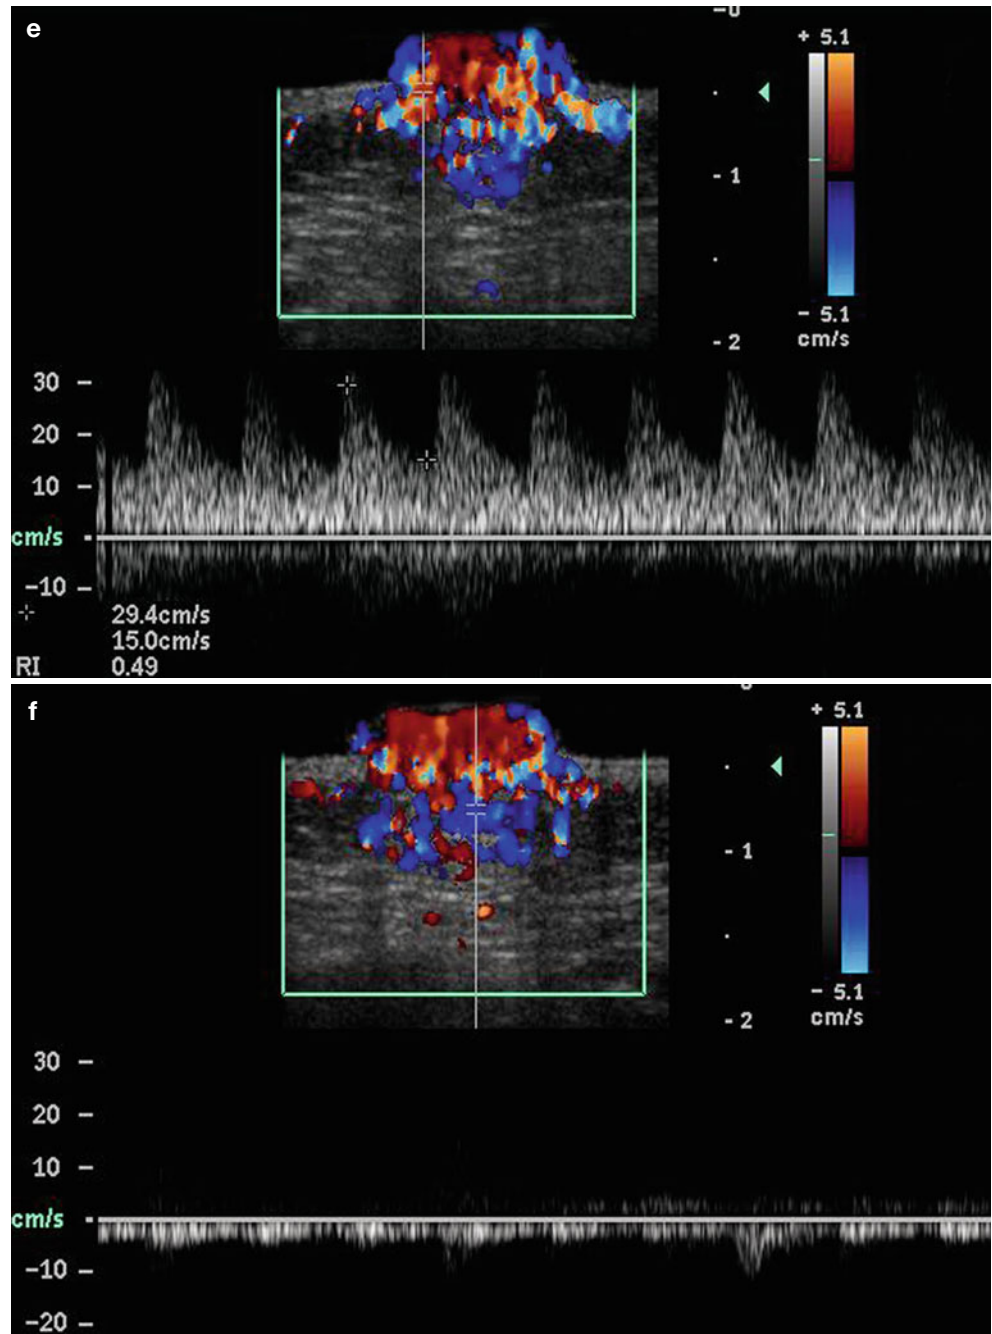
(a–f) Hemangioma (proliferative phase). (a) Clinical erythematous bump in the right cheek. (b) Grey scale ultrasound image (transverse view) shows hypoechoic tissue (*) in the dermis that displaces the epidermis upward. Hyperechogenicity of the subcutaneous tissue is also detected. (c) Color Doppler ultrasound image and (d)
